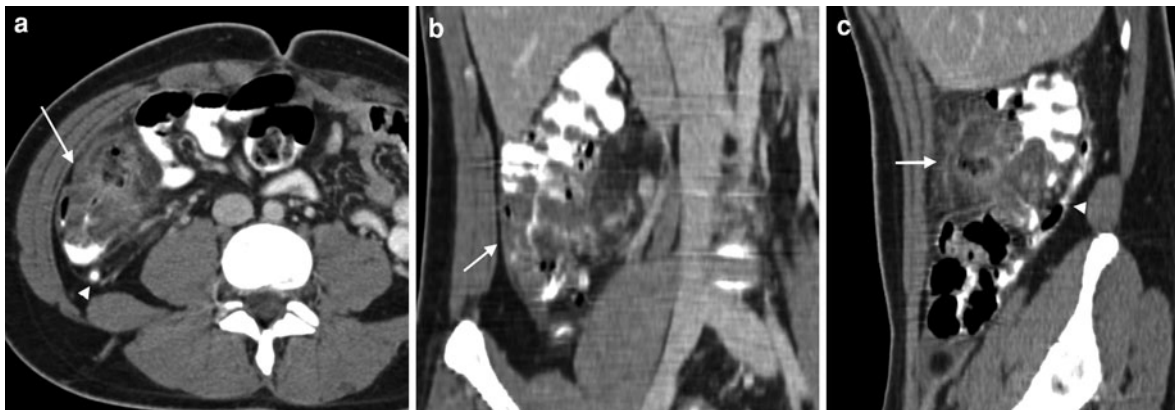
Transverse (a), coronal (b), and sagittal (c) CT images obtained with IV and oral contrasts in a patient suspected of acute appendicitis. Definite diagnosis is a right colitis with a
